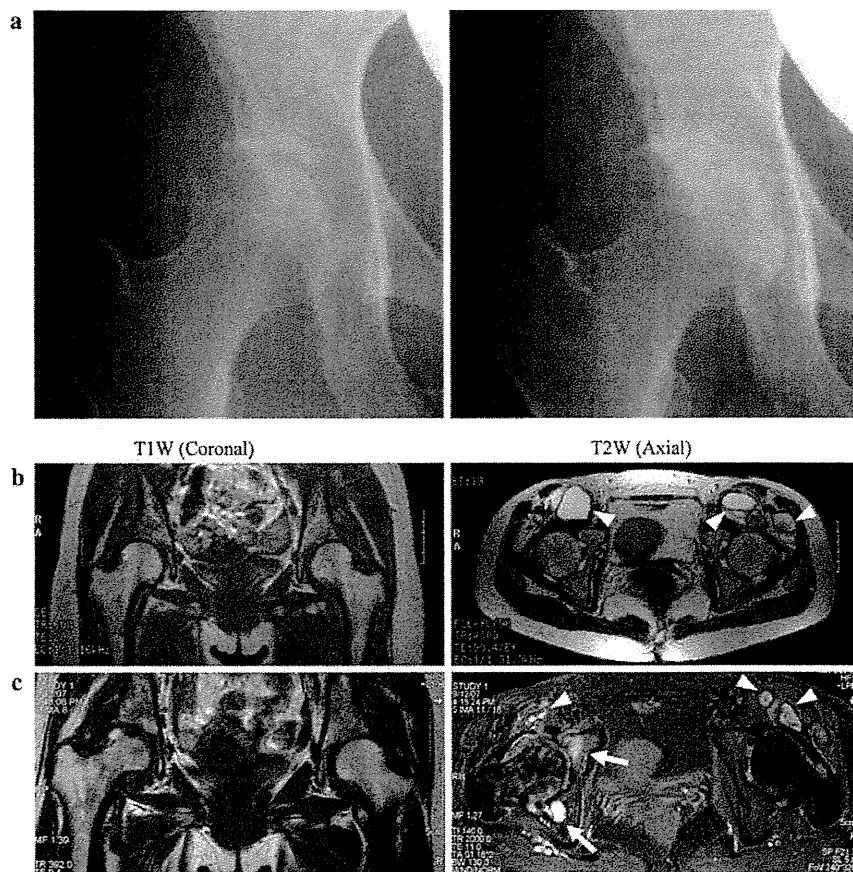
X-ray and coronal T1-weighted (*left*) and axial T2-weighted (*right*) MR images of the hip joints. a X-ray in December 2005 (*right*) and September 2007 (*left*). b MRI in January 2005 only showed extracapsular cyst (*arrowheads*). c MRI in September 2007 showed not only extracapsular cysts (*arrowheads*) but also joint destruction accompanied with cyst-like formation (*arrows*)
